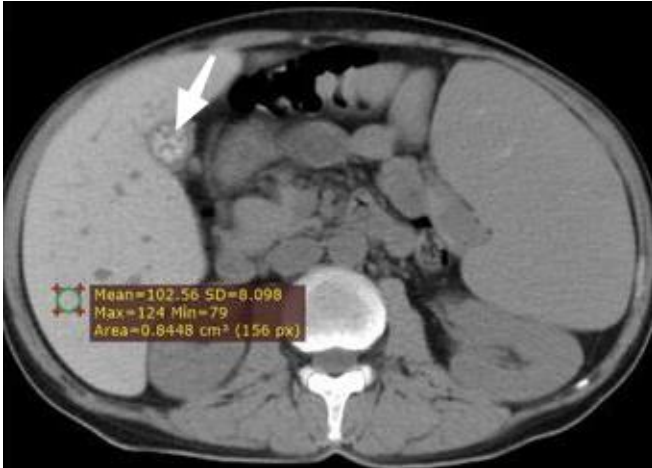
Axial non-contrast CT images of the abdomen show cholelithiasis (white arrows) and severe hepatosplenomegaly as well as severely siderotic liver with an average HU of 103 secondary to transfusional siderosis (normal liver attenuation should be approximately 54–60 HU).
